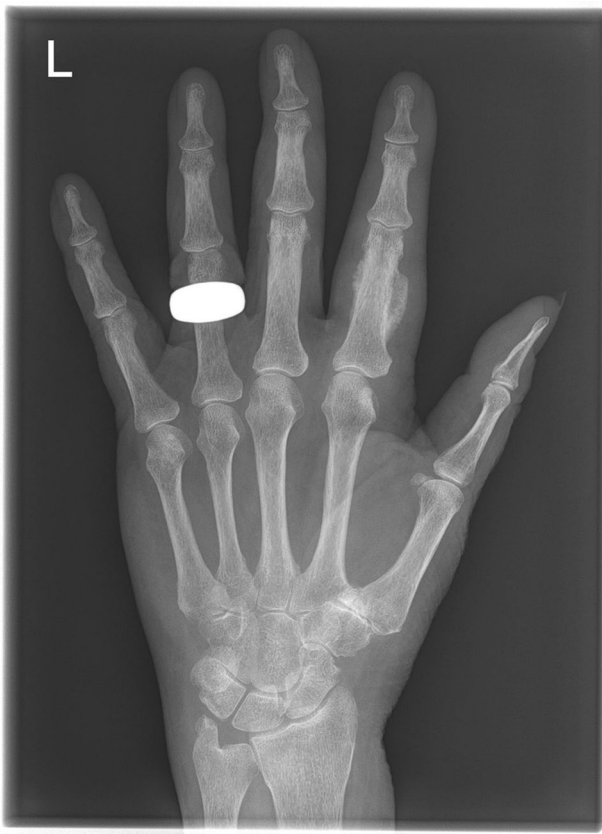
Radiograph of left hand
